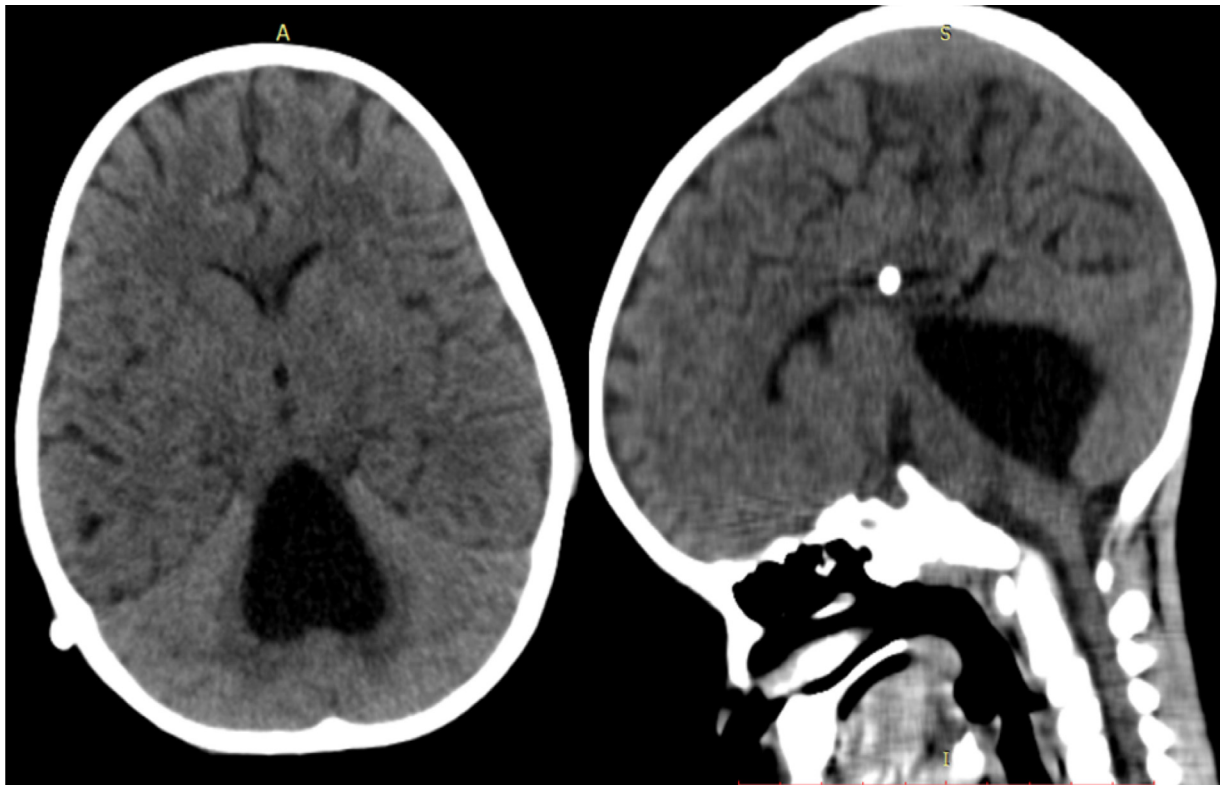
Brain CT scan showing dilated fourth ventricle and slit lateral and third ventricles.
